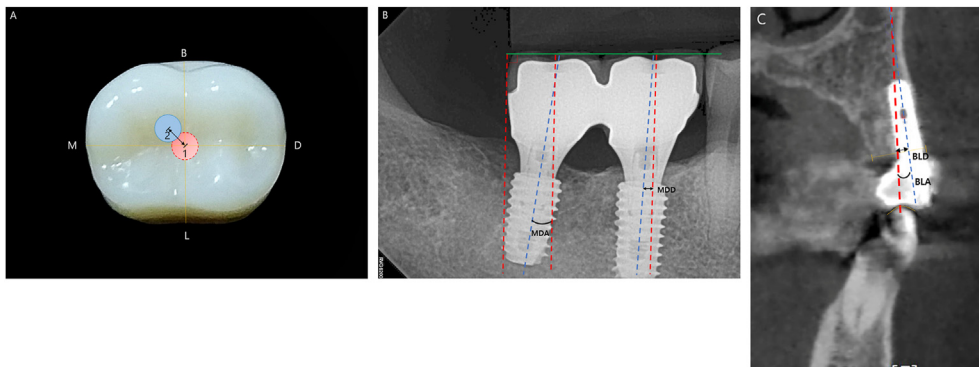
Measurement of positional accuracy. (A) Occlusal view of the implant prosthesis. The central position was measured. (B) Mesio-distal view on periapical radiographs. MDA and MDD were measured. (C) Bucco-lingual view on cone-beam computed tomography images. BLA and BLD were measured. Red circle, position of ideal screw hole; blue circle, position of actual screw hole; green line, occlusal plane; red line, ideal long axis; blue line, actual long axis; MDA, mesio-distal angulation; BLA, bucco-lingual angulation (or bucco-palatal angulation); MDD, mesio-distal distance; BLD, bucco-lingual distance (or bucco-palatal angulation).
